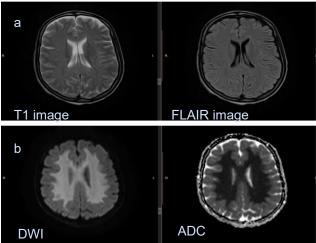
(a) Subcortical U-fibers are more prominent than expected on a standard T2 MRI and fluidattenuated inversion recovery (FLAIR) MRI images. (b) Diffusion-weighted image (DWI) shows diffusely increased signal in white matter confirmed as a true restriction on apparent diffusion coefficient (ADC) map.
